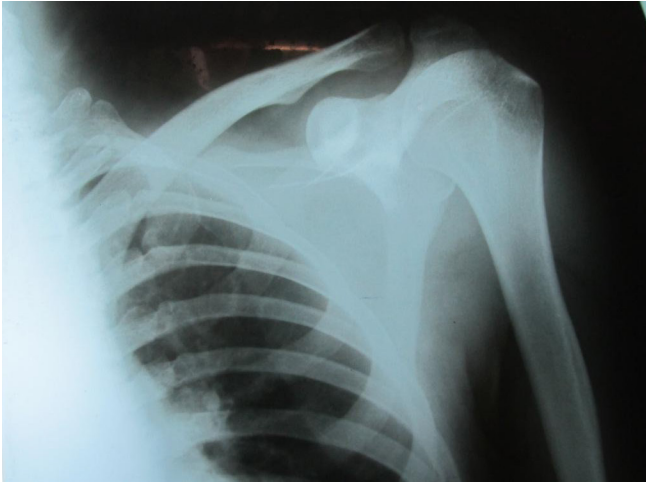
plain radiography of antero-posterior view of left shoulder.
